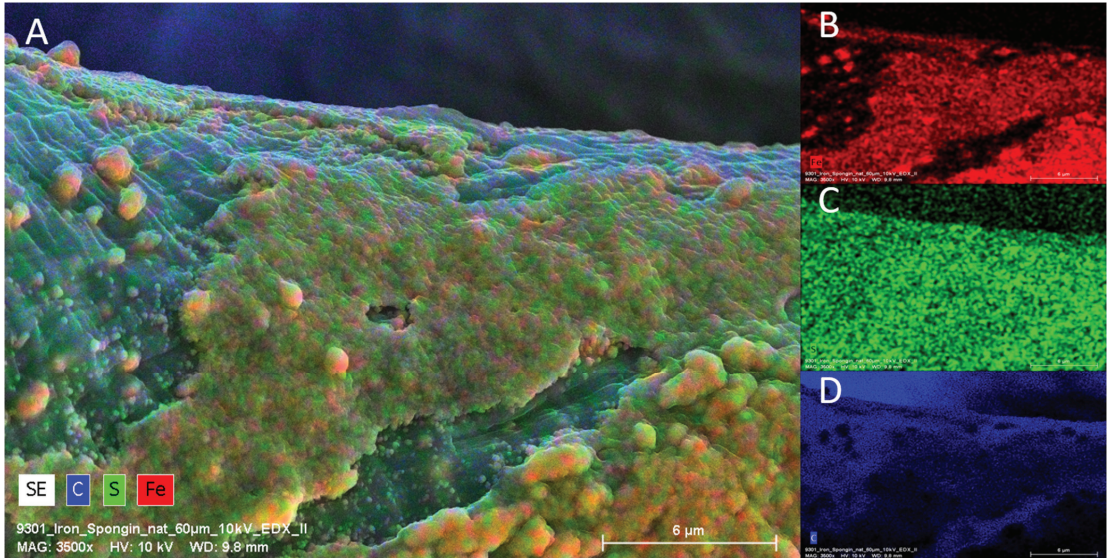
EDX Analysis (elemental mapping) of a single fiber of an “Iron-Spongin after ultrasound treatment” sample. Clearly visible is the presence of Fe and S on the surface of the scaffold strain (A). Fe is predominantly deposited in the crust-like structure (B), whereas sulfur is more or less equally distributed over the surface (C). C is present on the whole sample due to the organic compounds of the sample and of carbon coating used for SEM (D).
